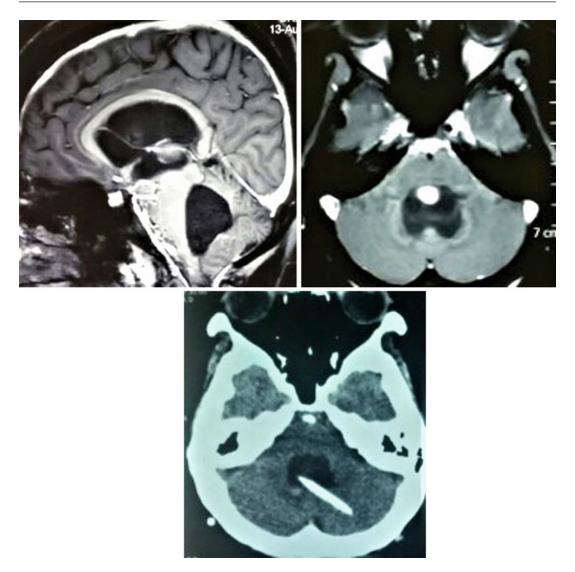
Trapped fourth ventricle presenting with headache after relief of hydrocephalus with a VP shunt 18 months earlier. Sagittal and axial post-contrast MR images showing an isolated fourth ventricle. A fourth
